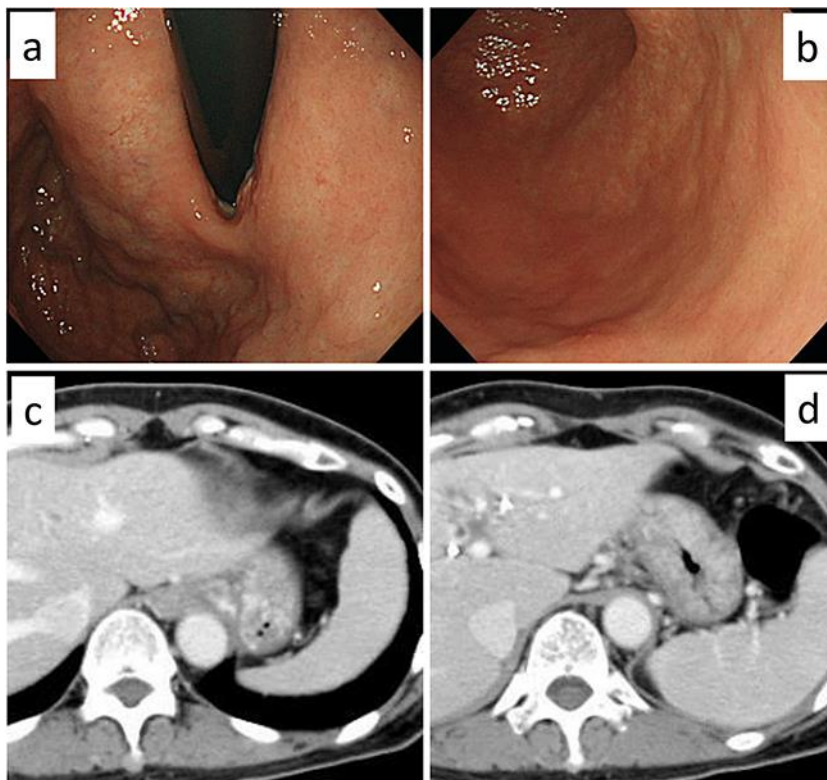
a, b Gastroscopy showed reduction tumor extremely and thin-walled. c, d CT showed ascites disappearance and well-controlled tumor.
